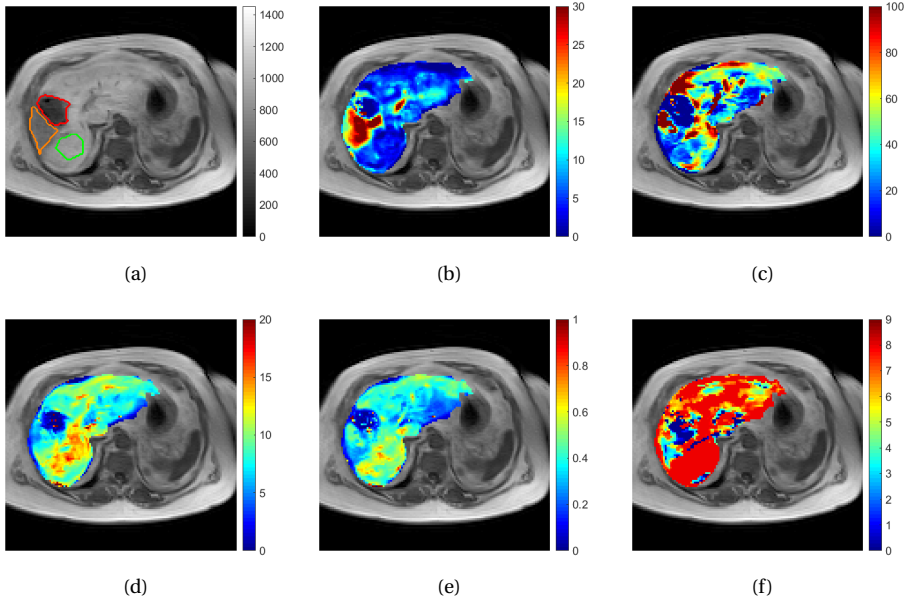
(a) A post-contrast DCE-MR image with three region of interest (ROI) delineated, which represent healthy liver tissue (green), tumor type I (orange) and type II (red), respectively. (b)-(f) represent PKM parameter maps which are overlaid on image (a). (b) and (c) are F_A and F_V , i.e. the arterial and venous plasma flows, respectively (in milliliters per minute per 100 mL). (d) shows K_I , the liver uptake rate (in per minute). (e) represents extravascular extracellular compartment K_E (in milliliters per 100 mL). (f) stands for T_A , the time delay of the Gd-EOB-DTPA's arrival between in the aorta and liver (in second).
